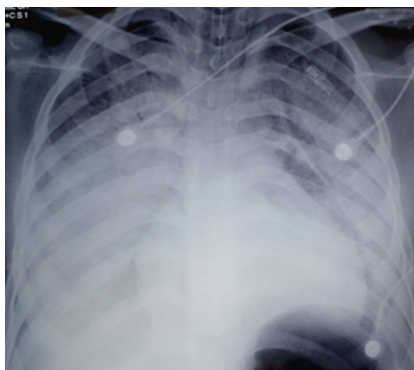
Chest X-ray Before Treatment.
